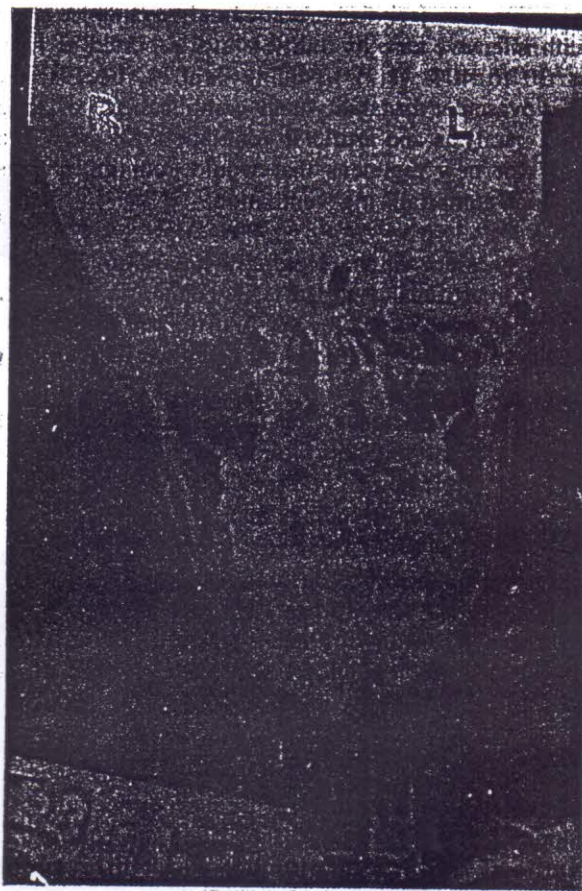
X-ray of mother's face showing mild asymmetry and hypoplasia of the right mandible.
